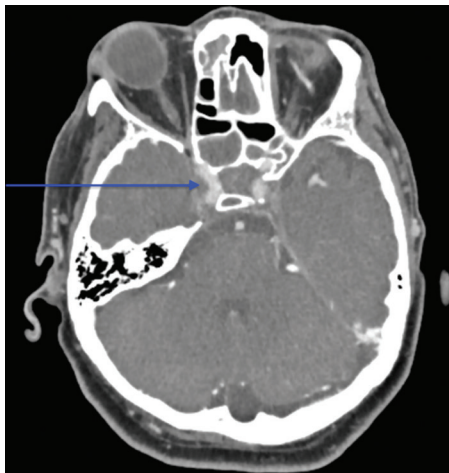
Computed tomography venography. The blue arrow highlights a small filling defect in the right internal jugular vein that appears darker (hypodense) than the left internal jugular vein, which appears well-opacified and bright, indicating normal blood flow with contrast filling. This darker appearance on the right indicates the absence of contrast filling in the vein, suggesting thrombus.
